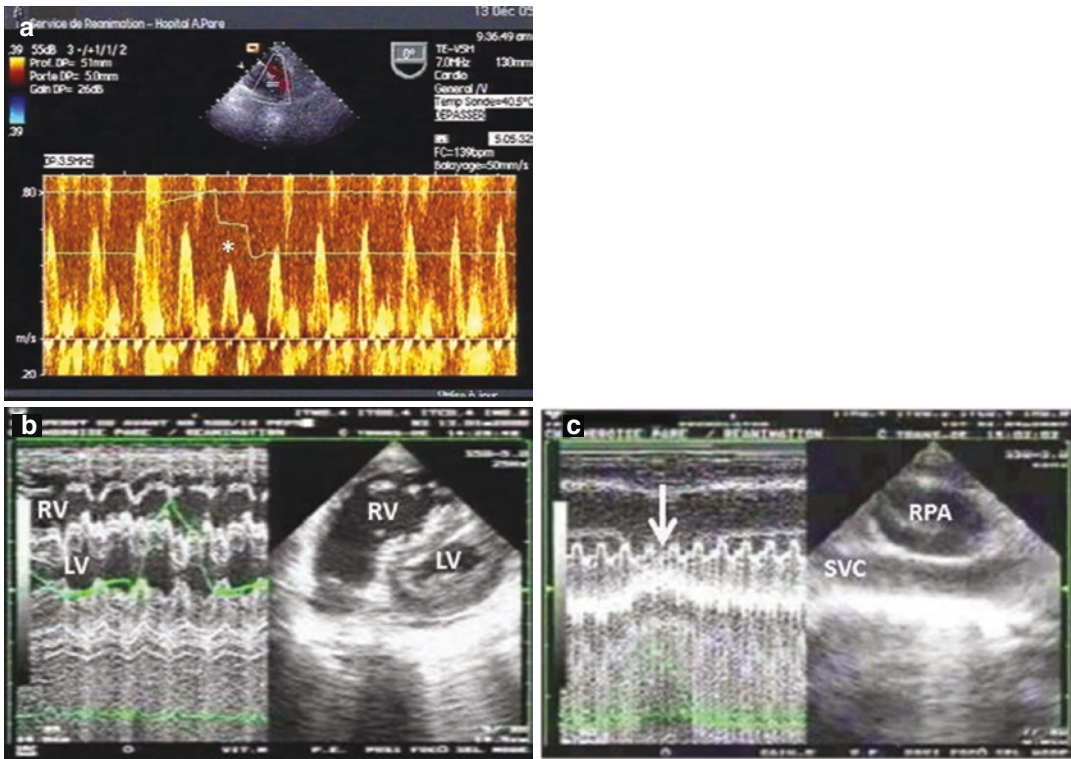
TEE in a ventilated patient with pulse pressure respiratory variations. Panel a: pulsed wave Doppler in the main pulmonary artery demonstrating significant decrease in RV ejection (Vmax and VTI) during tidal ventilation (asterisk). Panel b: Time-motion study in a short-axis transgastric view in a patient ventilated for ARDS
